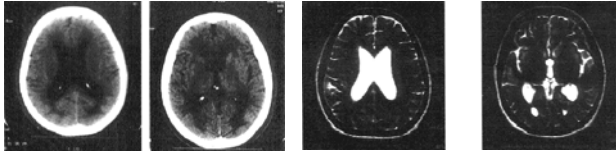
Computed tomography of brain shows (left) prominence of temporal horns and (right) enlargement of lateral and third ventricles
